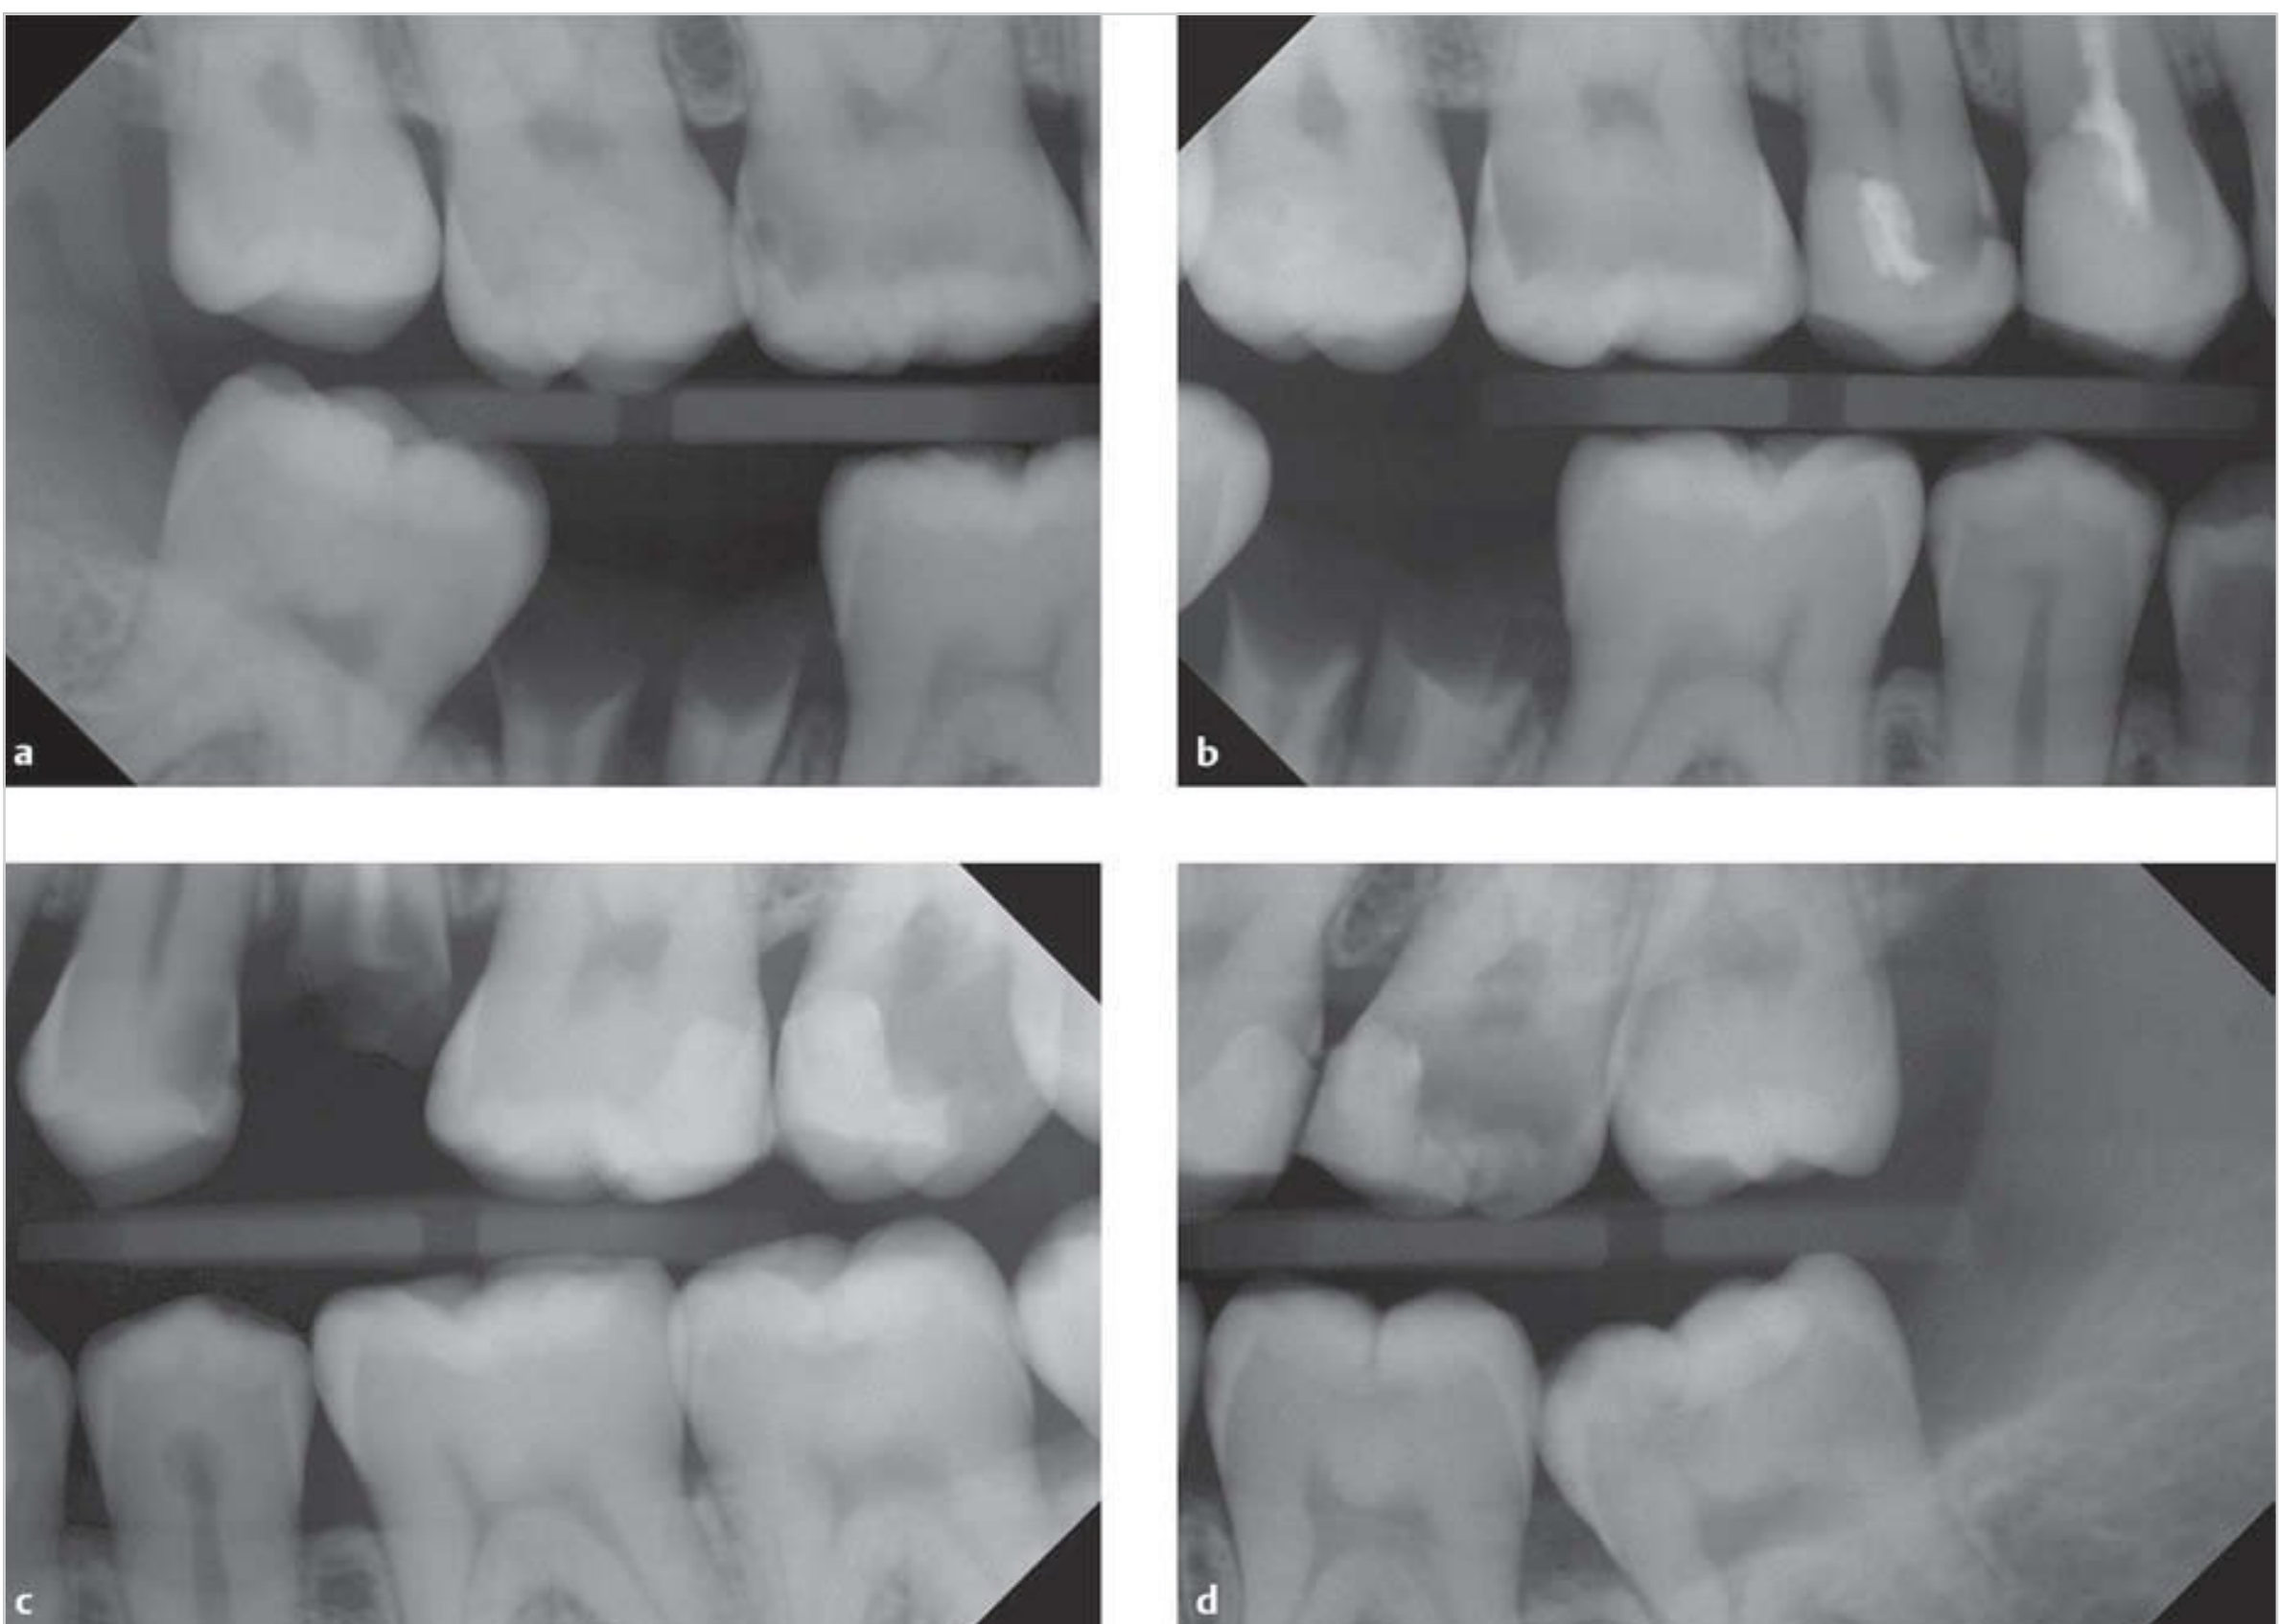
Bitewing radiographs.
